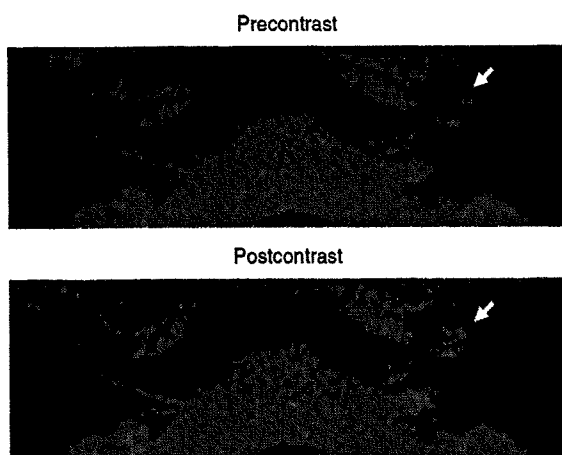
Patient no. 5, a case of atypical Bell's palsy (see Tables I and II). This patient had a mild hearing loss, tinnitus and dizziness with facial paralysis on his left side. He had no vesicle in his left ear. This patient showed high signals (arrow) in his left cochlea on both precontrast and postcontrast 3D-FLAIR.
